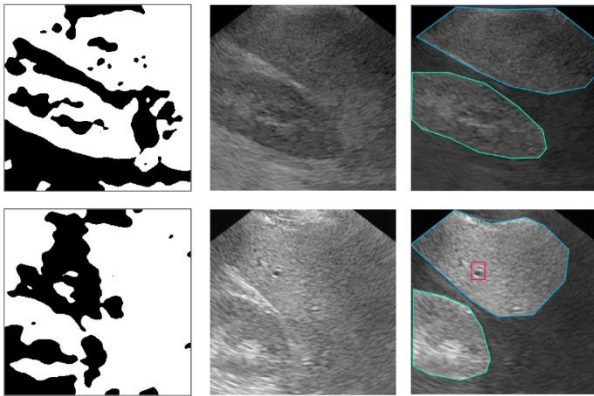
Qualitative examples of synthetic liver ultrasounds (middle) conditioned on semantic maps (left) and annotations by ROI (right)
